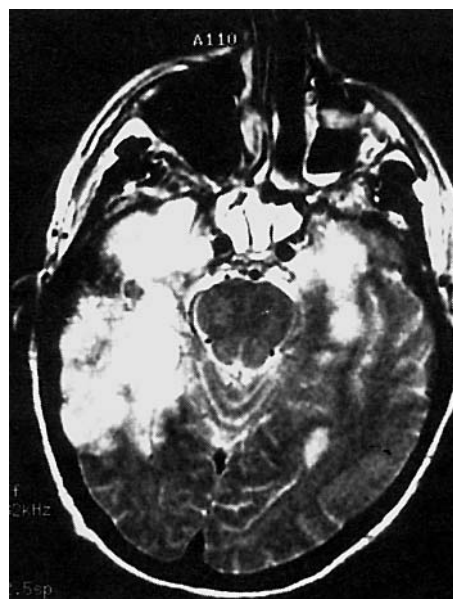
HSE. T2 weighted MRI showing extensive area of increased signal in right temporal lobe and lesser involvement of the left. Reproduced from Baringer¹⁰, with permission.
